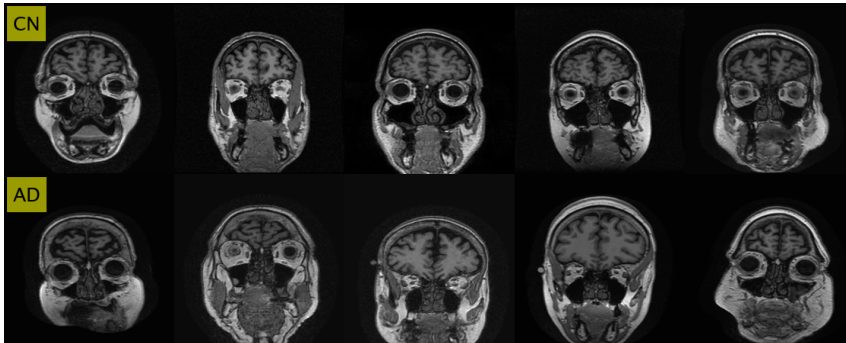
Coronal plane: MRI slice Nr. 62 for CN and AD. Best selection according to histogram descriptors.
